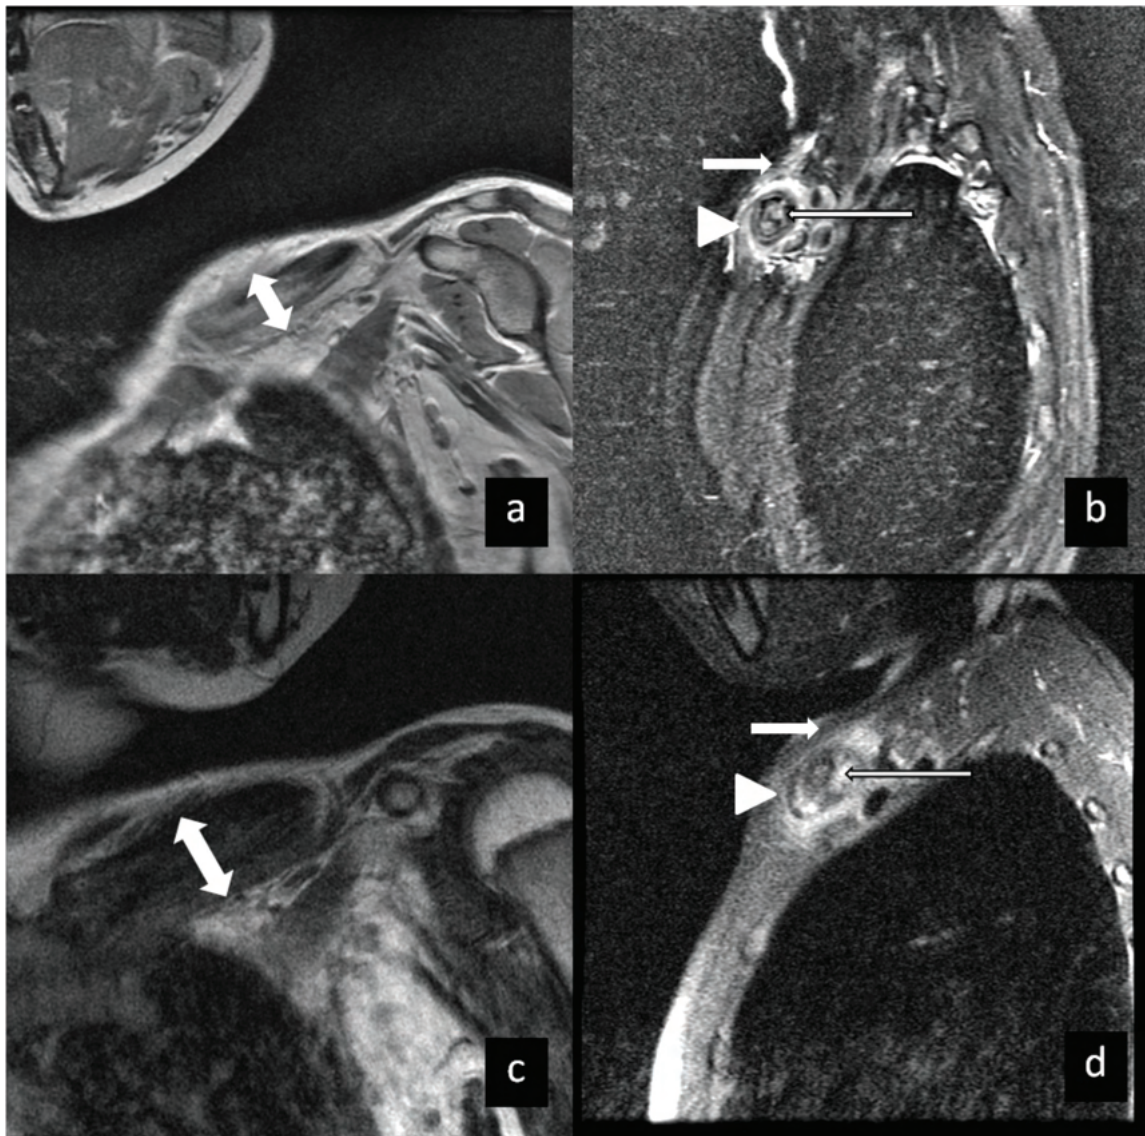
An 11-year-old girl (patient 2) with diagnosis of CRMO with local swelling and pain of the left shoulder. a and b, Coronal T1-weighted image (a) sagittal T2-weighted fat-suppressed image (b) of the left clavicle. There was a sclerotic expanded lesion (double arrow head) affecting the medial left clavicle with also BME (long arrow); grade 2 of BME size (according to its length, not shown here) and less than vessel/fluid of BME signal, circumferential periosteal (arrow head) and soft tissue edema (short arrow). c and d, Coronal T1-weighted image (c) and sagittal T2-weighted fat-suppressed image (d) of the left clavicle at follow-up MRI (about 7 months later since a and b). The follow-up MRI was ordered due to exacerbation of the left shoulder pain. Worsening of the MRI findings were depicted including BME (long arrow); grade 3 of BME size (according to its length, not shown here) and equal to vessel/fluid of BME signal, periosteal edema (arrowhead), soft tissue edema (short arrow) and cortical expansion (double arrowhead).
